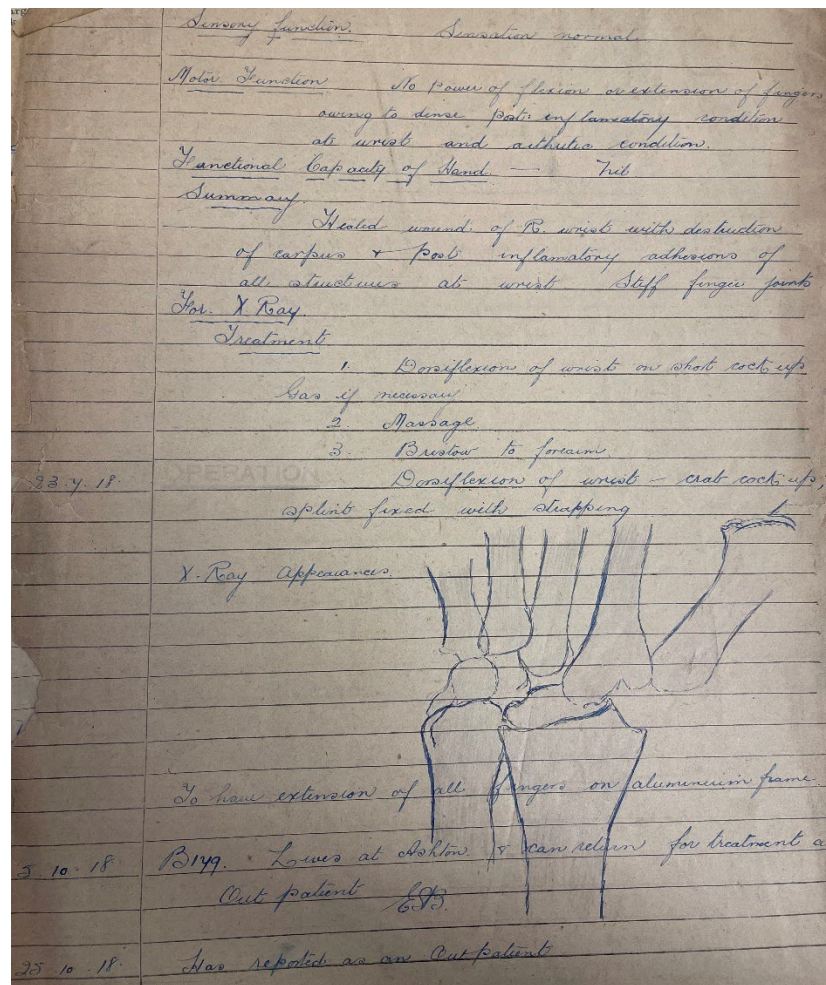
Example of an X-Ray appearance in the summary of a fracture treatment plan Source: Grangethorpe Hospital 1917-1926', *Papers of Sir Harry Platt*, University of Manchester Library.
